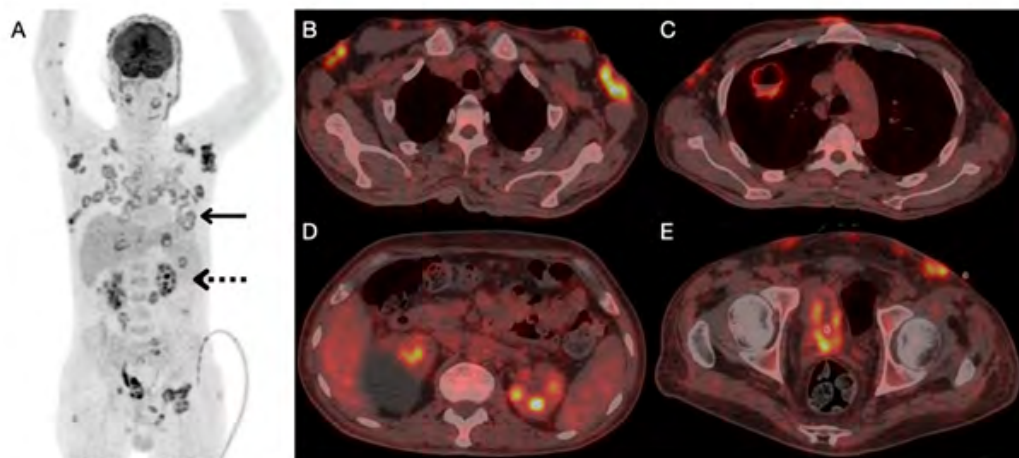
18F FDG PET/CT images of the patient. A: Maximum intensity projection image, depicting multiple FDG avid oval lesions, predominantly involving the thorax (solid arrow), as well as multiple foci of increased radiotracer uptake involving bilateral kidneys (dotted arrow). B-D: Fused 18F FDG PET/CT images of the patient. B: FDG avid skin and subcutaneous lesions involving thorax and bilateral axilla. B: Peripherally FDG avid cavitary lesion involving the right lung upper lobe. C: Multiple foci of FDG uptake involving both kidneys. Ancillary evidence of right simple renal cyst. D: Focal hypermetabolism involving the thickened urinary bladder wall.
